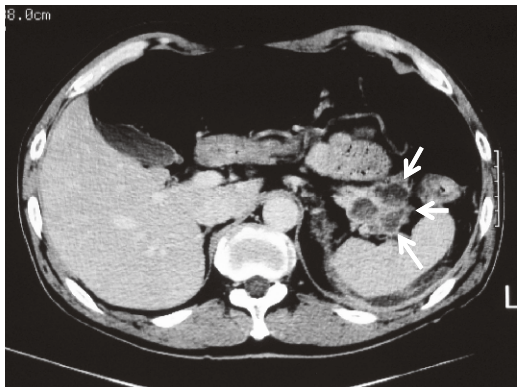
Five years before, multiple pseudocysts in the tail of the pancreas were demonstrated on CE-CT (arrows).
